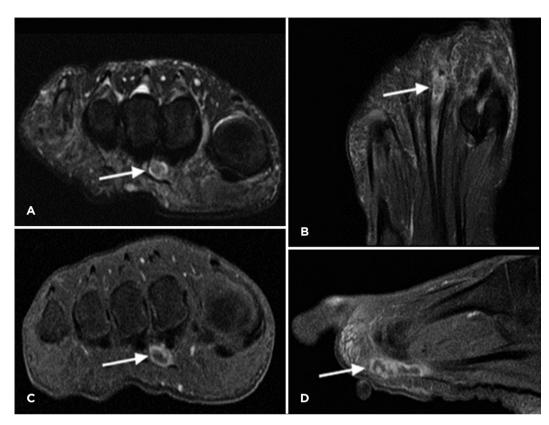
MRI sequences in a 47-year-old woman who practices regular walks with plantar pain which is worse while walking. Coronal (A) and axial (B) fs T2-w sequences show enlargement and perivascular edema in the second intermetatarsal vein (arrow). Coronal (C) and sagittal (D) fs T1-w postcontrast also show perivascular edema and a filling defect in the intermetatarsal veins. Note that edema follows the neurovascular plexus and is not in the plantar fat, differing from bursitis.
